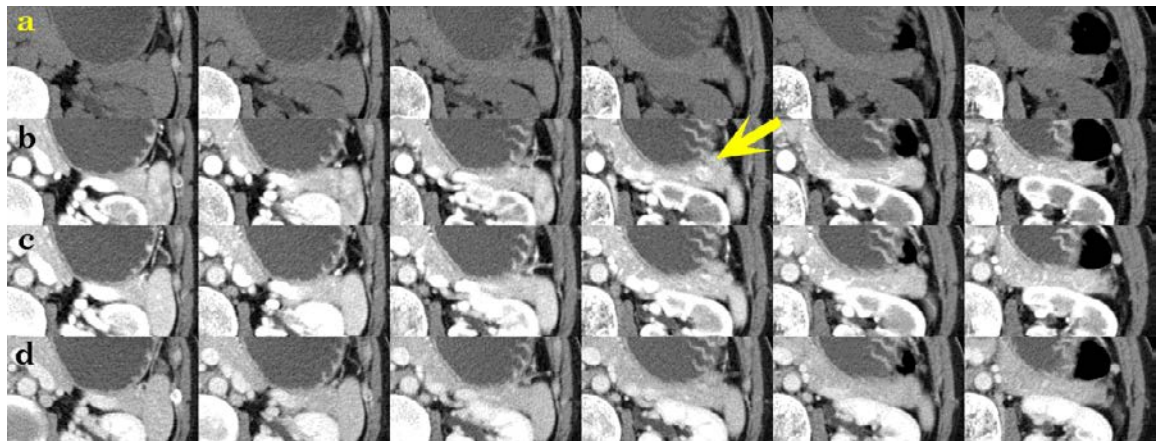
Axial CT scan of patient 1 (slice thickness: 3 mm) at 0 seconds (pre-contrast) (a), 35 seconds (b), 55 seconds (c), and 80 seconds (d) after the administration of contrast agent, respectively. Although images of (a), (c), and (d) show no remarkable findings, only one slice in series (b) shows a well-enhanced small mass in the tail of the pancreas (indicated by a yellow arrow).
